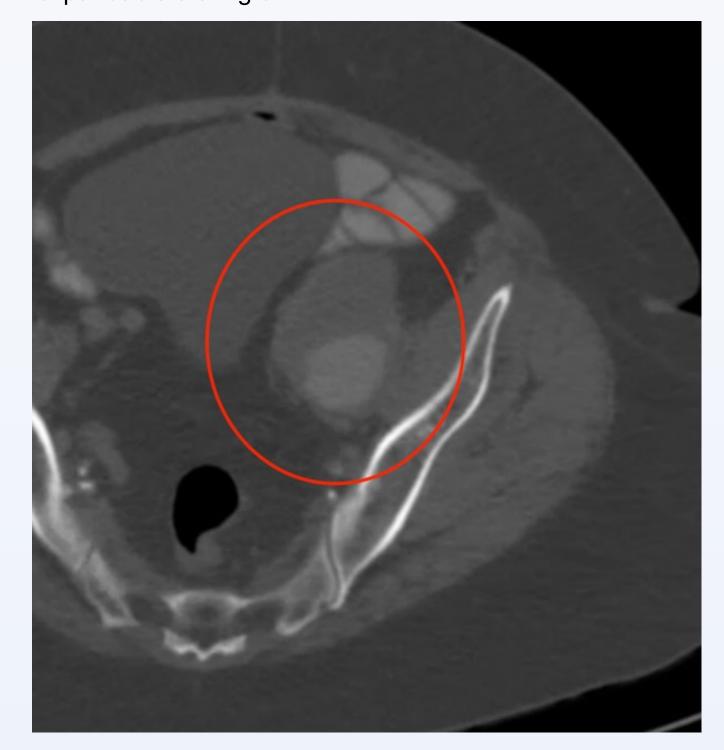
CT Scan showing pseudoaneurysm
